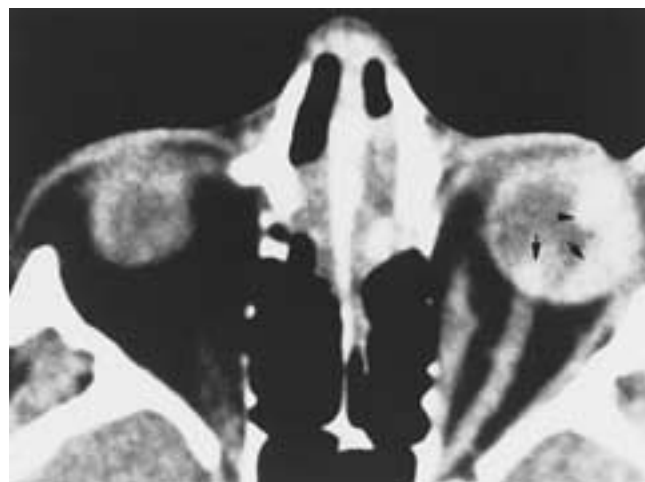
Acute choroidal hemorrhage (detachment). Axial CT scan shows choroidal hematomas (*arrows*).
